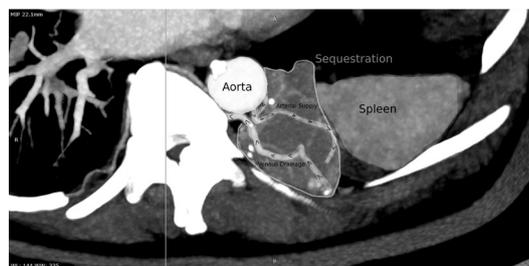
CT image showing left lower lobe mass with labelled segmentation of vessels.
